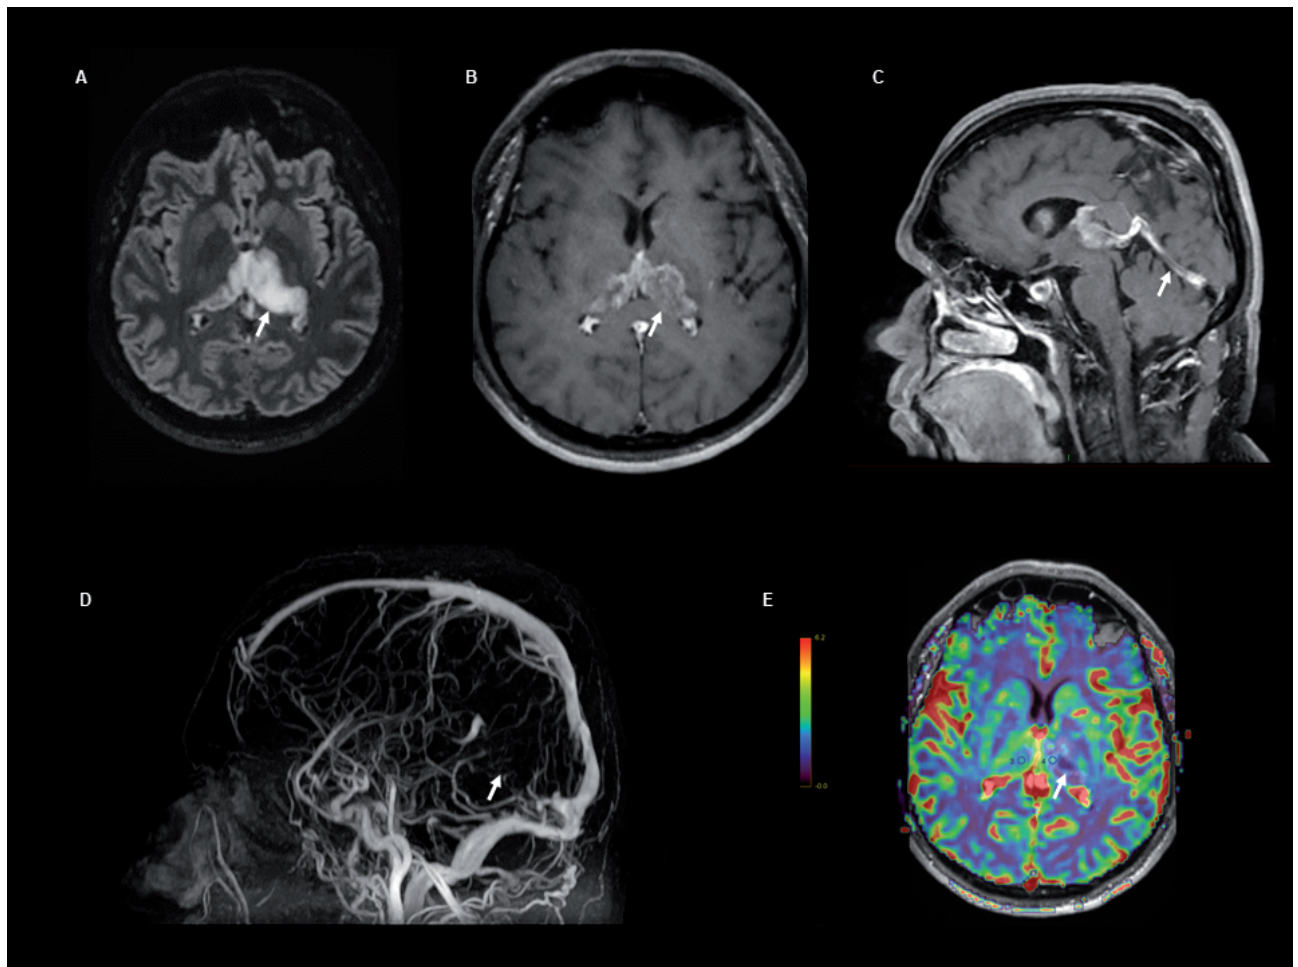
Brain imaging of the patient. A) T2-weighted FLAIR sequence displaying bilateral thalamic hyperintensity; B, C) T1-weighted gadolinium enhanced sequences revealing delayed thalamic contrast enhancement due to blood–brain barrier breakdown (B) and filling defect within the straight sinus (C); D) Magnetic resonance venography depicting lack of flow within the straight sinus; E) Magnetic resonance perfusion imaging displaying a decreased cerebral blood volume in the infarcted thalami.
